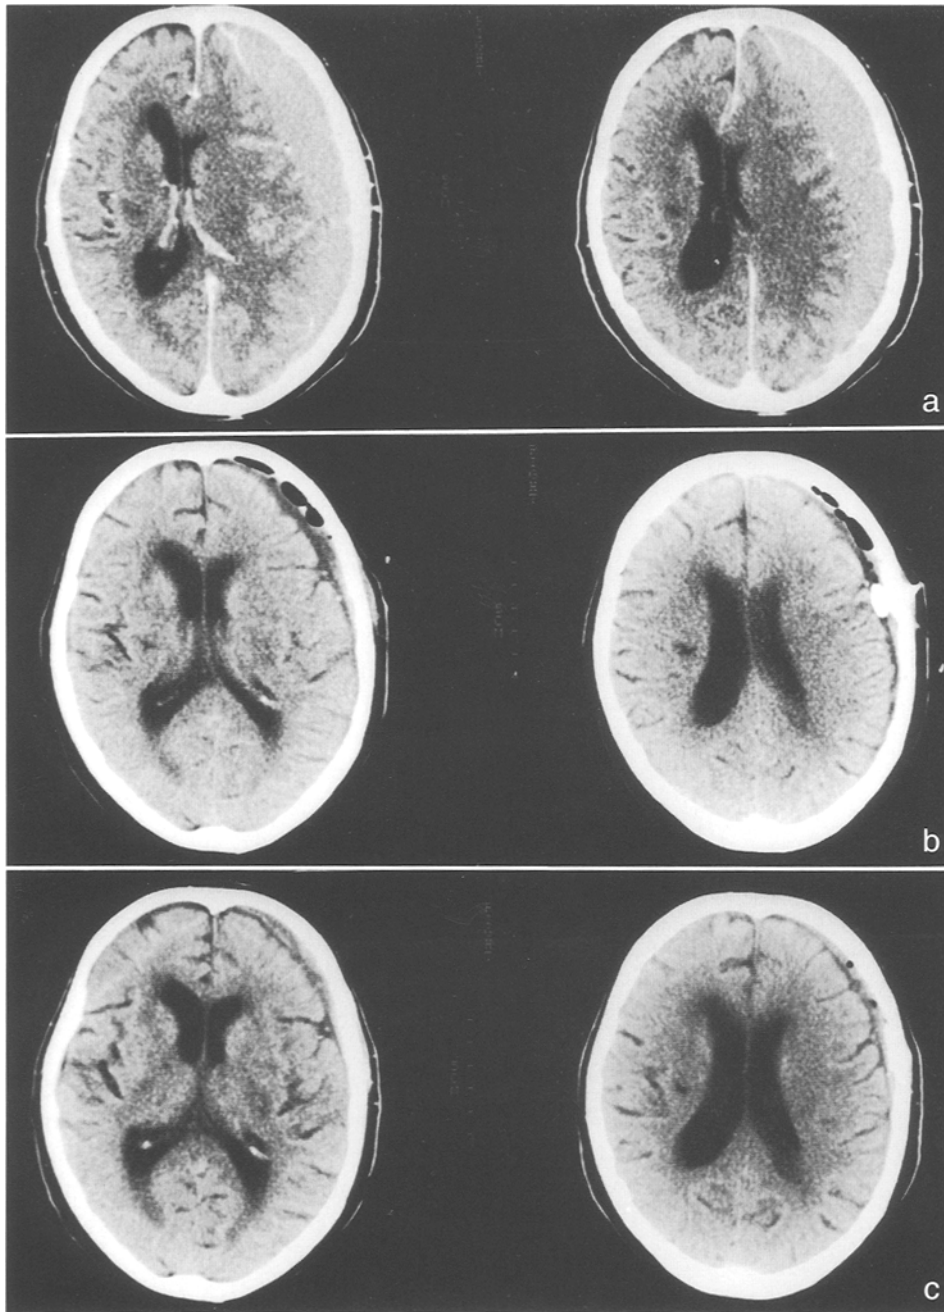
Ideal follow-up after TDT-technique. (a) Isodense subdural haematoma with ≥ 2 cm width, ipsilateral cortical and ventricular compression, and midline shift of ~ 1 cm. (b) CT-status on day 1 with the umbrella-like catheter-tip placed in the subdural space, return of the midline structures, ventricular and cortical re-expansion. Discrete residual hypodense subdural effusion of ~ 1 cm and small air-bubbles. (c) Status on day 10 shows almost total disappearance of the subdural effusion with intact cortical mantle, normal-sized ventricles and intact midline structures
